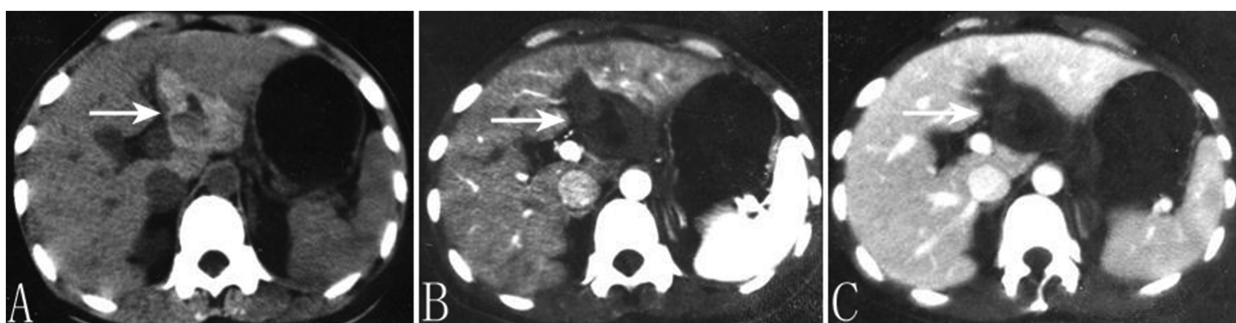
CT findings. (A), CT plain scan performed between left liver edge and stomach displayed a polygonal, slight high-density shadow with a smooth and clear edge and irregular low-density region in the middle. (B), Enhanced CT of the focus shows no sign of intensification during the arterial phase with a smooth and clear edge and lower-density region in the middle. (C), No sign of intensification during the venous phase.
